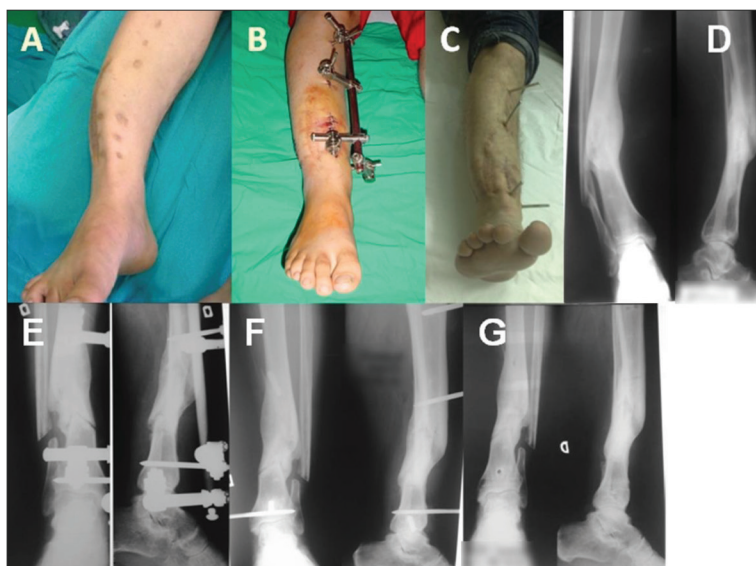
A – Leg of the 29-year-old male patient with posttraumatic varus malunion, before correction; B – The same patient after correction using Mitkovic type external fixator; C – External fixator was removed 100 days after the correction surgery; D – X-rays (anteroposterior and lateral view) of varus (26°) and antecurvatum malunion, 20 months after injury; E – X-rays (anteroposterior and lateral view) one month after tibial and fibular corticotomy, correction of the deformity and application of the Mitkovic type external fixator; F – X-rays (lateral and anteroposterior view) three months after corticotomy and external fixation; G – X-rays (lateral and anteroposterior view) 100 days after correction of the malunion
